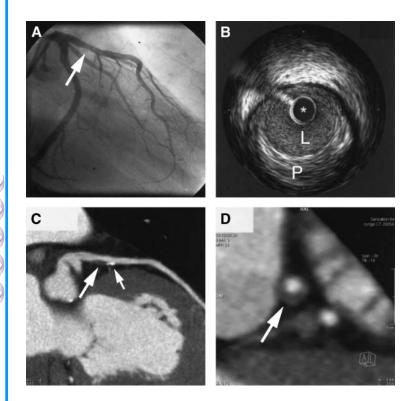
Visualization of coronary atherosclerotic plaque by 64 slice computed tomography (CT). A: Coronary angiography shows mild eccentric lumen reduction in the proximal left anterior descending artery (arrow). B: IVUS demonstrates the presence of eccentric noncalcified coronary atherosclerotic plaque. L, lumen; P, plaque. The asterisk indicates the IVUS catheter. C: Contrast-enhanced 64 slice CT shows the proximal left anterior descending artery in a multiplanar reconstruction. At the site of lumen reduction, a coronary atherosclerotic plaque with positive remodeling can be seen (large arrow). A small calcification is present toward the distal border of the plaque (small arrow). D: Cross-sectional view of the lesion at the site of maximum plaque area by CT, demonstrating the bright, contrast-enhanced lumen and the eccentric plaque (arrow). Reproduced with permission from Achenbach Ed Comment, JACC 2005; 46: 156.
